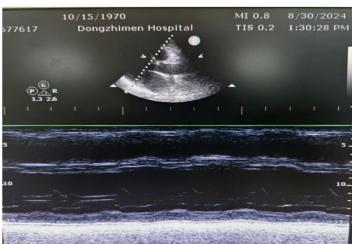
Echocardiogram on admission
